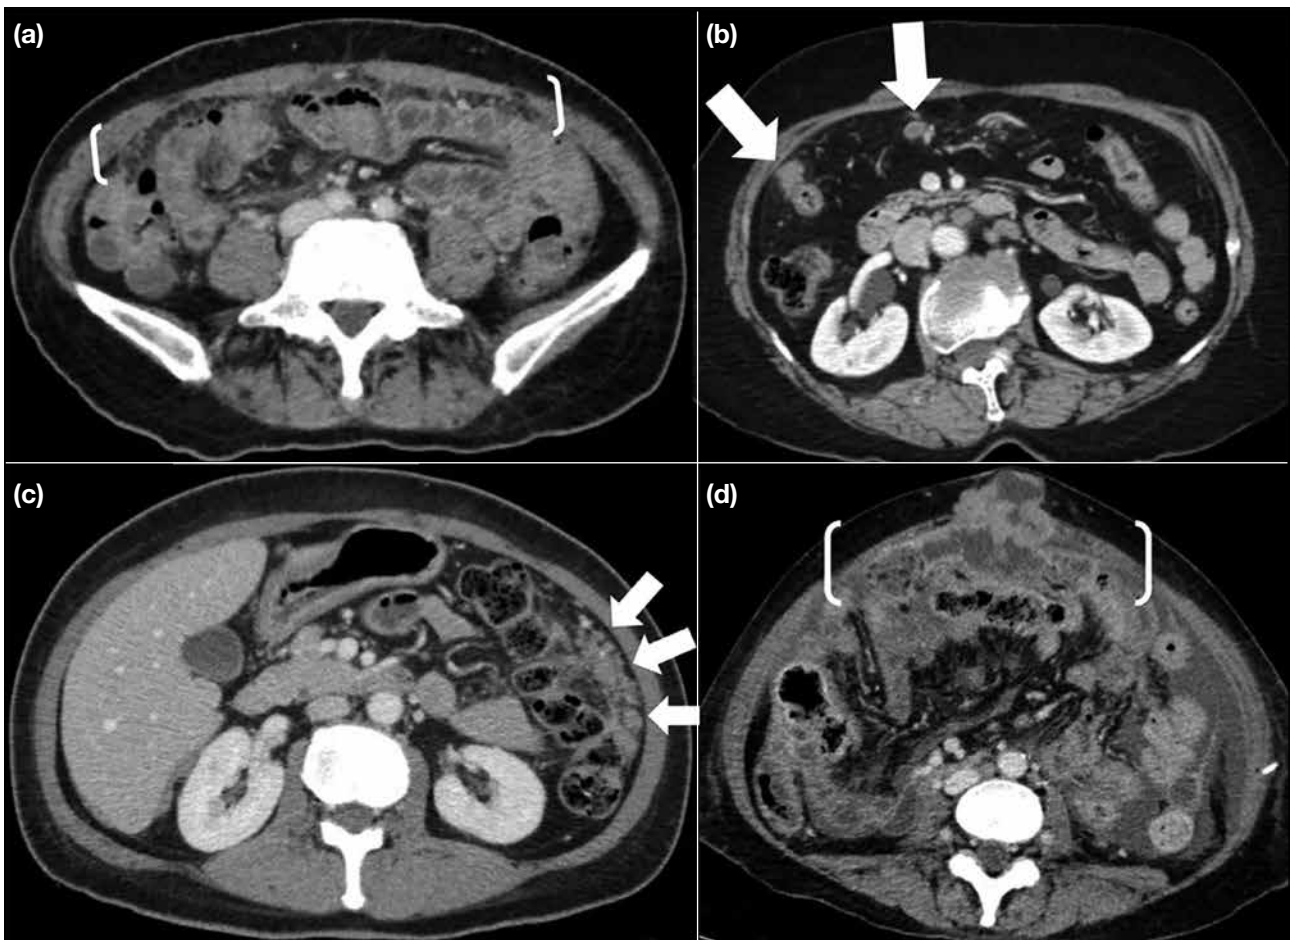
Contrast computed tomography images demonstrating the different morphologies of omental deposits, from mild increased stranding at the omentum (brackets in [a]), small omental nodules (arrows in [b]), confluent nodules and plaque-like deposits (arrows in [c]), to omental cake appearance with extension to the umbilicus (brackets in [d]).
